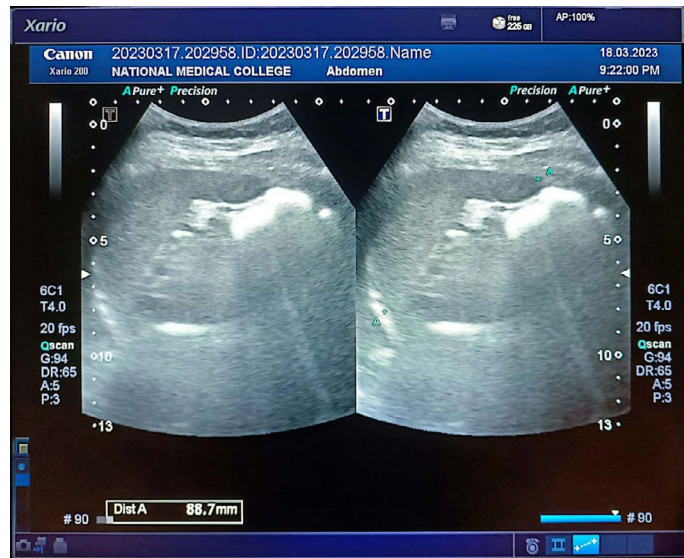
Ultrasonographic Measurement of splenic length.
